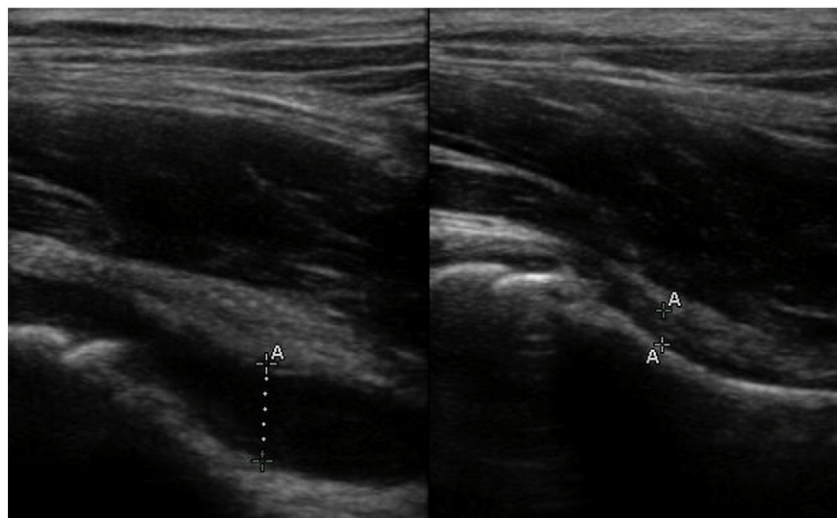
Ultrasound of a patient with septic arthritis showing effusion and normal contralateral hip. On the left is an ultrasound of a hip with an effusion, and the picture on the right is the contralateral side of the patient. The side with the effusion measures greater than 5 mm and is greater than 2 mm larger than the contralateral side, both of which alone indicate an effusion.
